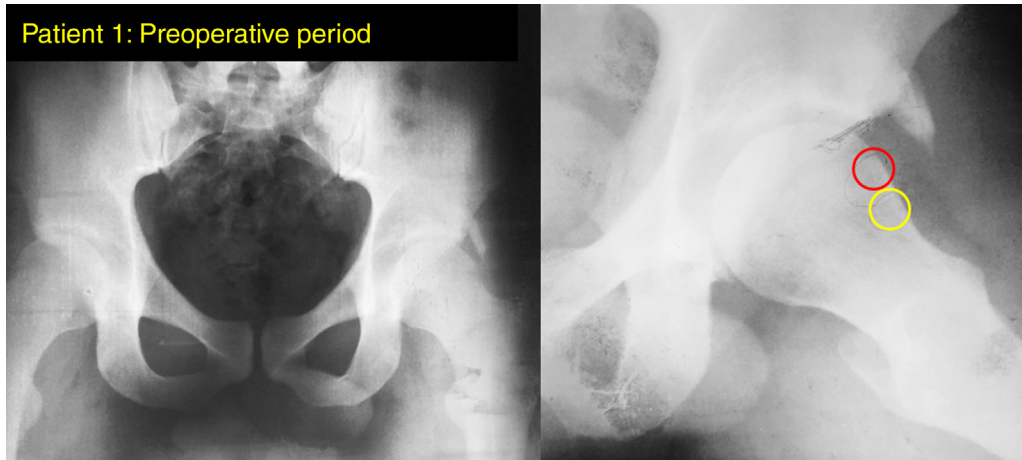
Hip radiographs of patient 1 on AP and iliac oblique views. The arrows point to AIIS deformity (Hetsroni Grade III),⁶ and the circles indicate the presence of synovial herniations in different topographies of the femoral neck, with impingement in different portions of the pelvis.
